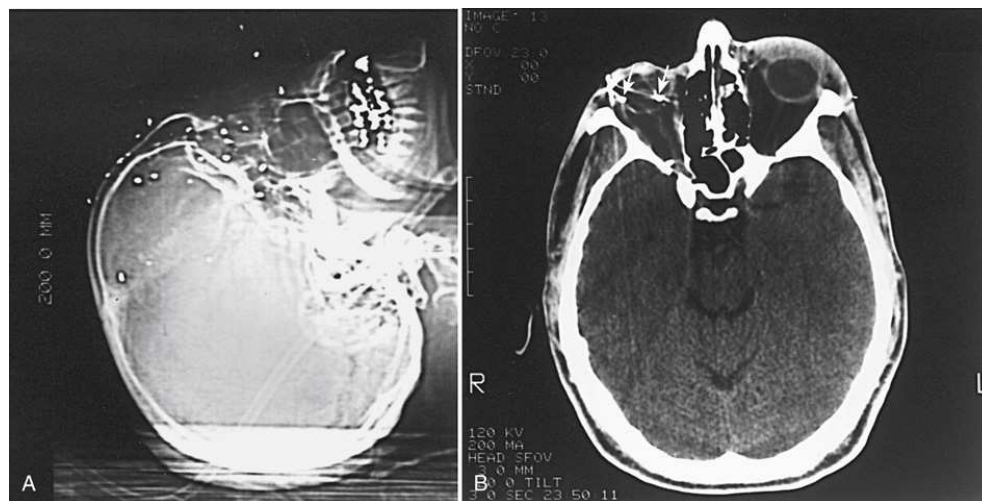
(A) Lateral localizer CT image showing multiple buckshot in the face. (B) Axial CT image of same patient, showing shotgun pellets within the eye (arrows).
